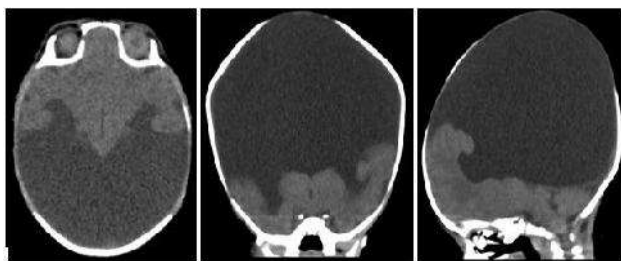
CT brain: Absent anterior cerebral falx, absent septum pellucidum, fused lateral ventricle with gross hydrocephalus (non-communicating) and partially fused thalami
